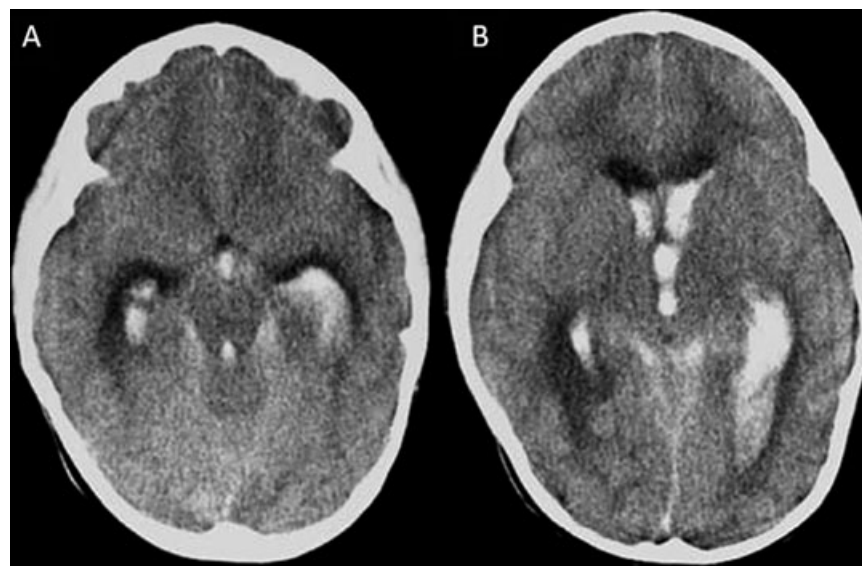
Axial CT images (A, B) show posttraumatic blood products within the ventricular system including Sylvian aqueduct after high-speed TBI. Moderate hydrocephalus is noted as complication of the IVH.
